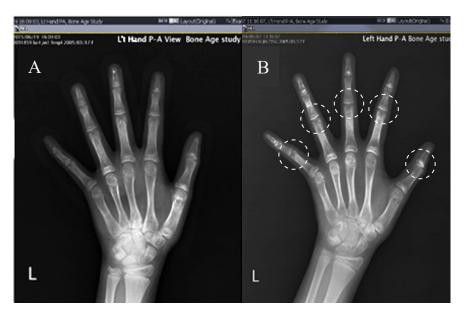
The left-hand bone age analysis revealing by X-ray imaging for a representative patient receiving conventional GnRH-a therapy before and after Chinese herb medicine protocol. The bone age imaging was taken for the subject at the age of ten years and three months (A) and eleven years and three months (B) There was a significant promotion in bone age characteristic study as indicated by the white dashed circles.
